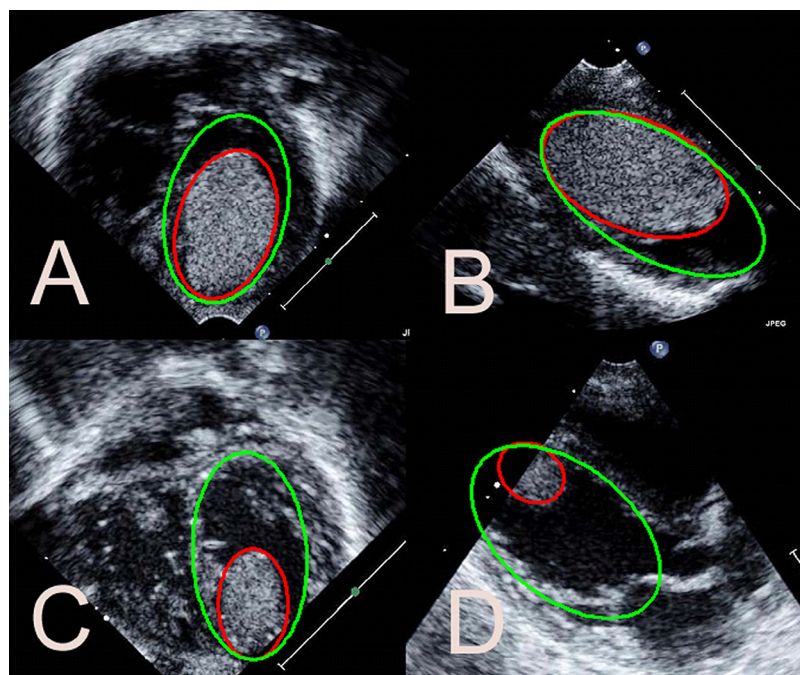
Large cardiac rhabdomyoma in a newborn occupying a significant volume of the left ventricle at birth in the apical 4-chamber view (A) and long axis view (B). At 1 month following everolimus therapy, the rhabdomyoma had shrunk significantly in size (same views, respectively, C and D). The green shapes approximately delineate the left ventricular cavity, and the red shapes delineate the rhabdomyoma.
